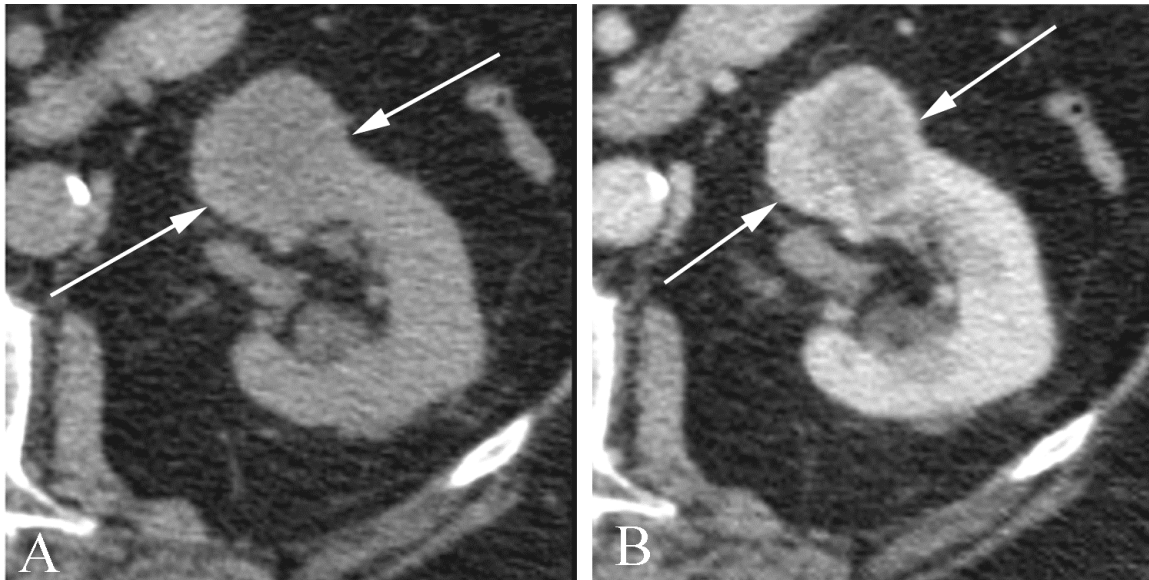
Renal cancer in a 76 year old man with hematuria. A. Unenhanced CT shows an exophytic mass (arrows) of the left kidney. B. Enhanced CT shows heterogeneous enhancement of the mass (arrow). Renal cell cancer was found at surgery.
